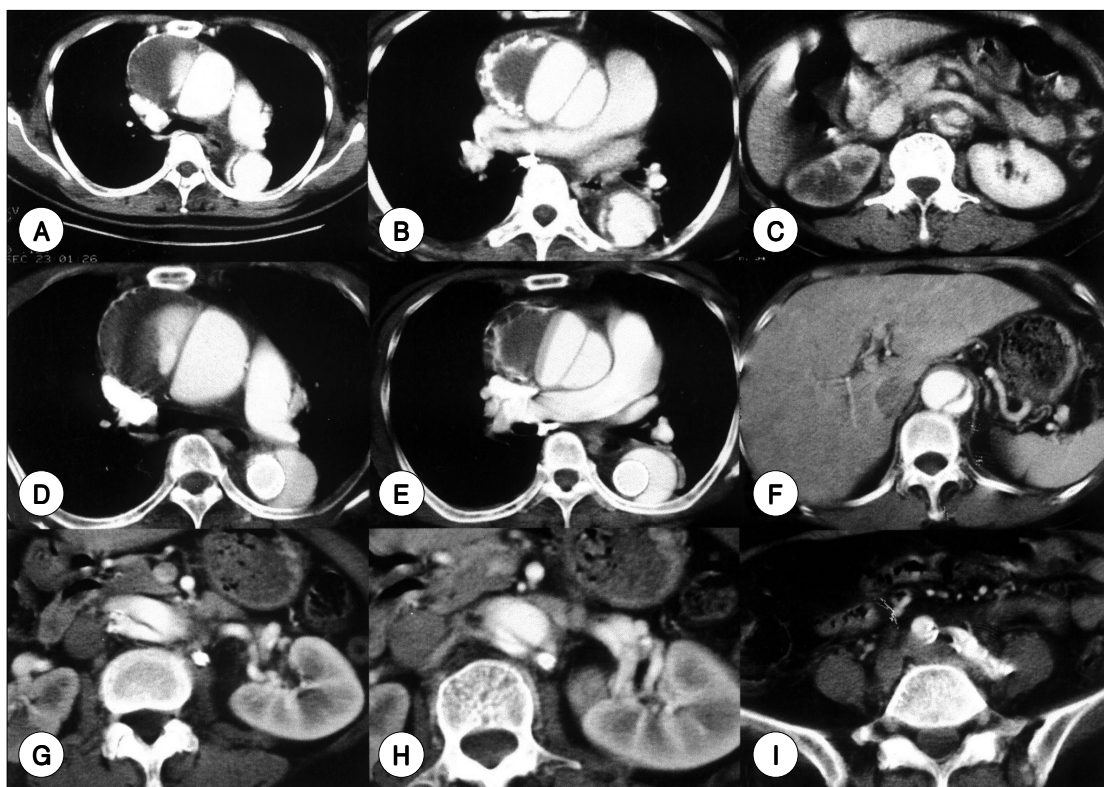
Initial chest and abdominal CT scan (A-C) show dilated ascending aorta (=10c m) and descending aorta (=4.1 cm) separated with true lumen and false lumen by intimal flap. Follow-up chest and abdominal CT scan, 3 months after the procedure (D-I) show well preserved perfusion flow in the true lumen of descending aorta, both lower extremity and left renal artery and no more increased size of false lumen.
